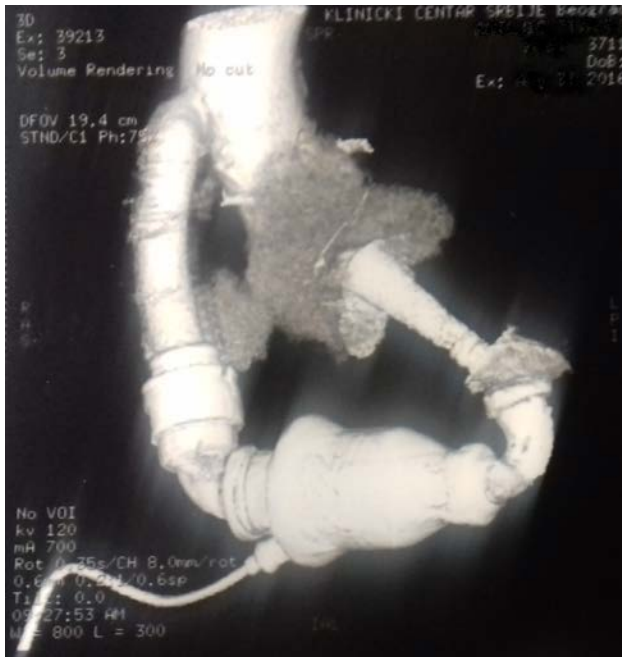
Multislice computed tomography (MDCT) of the chest – the outflow graft connection to the ascending aorta and the inflow cannula to the left ventricle are competent.
